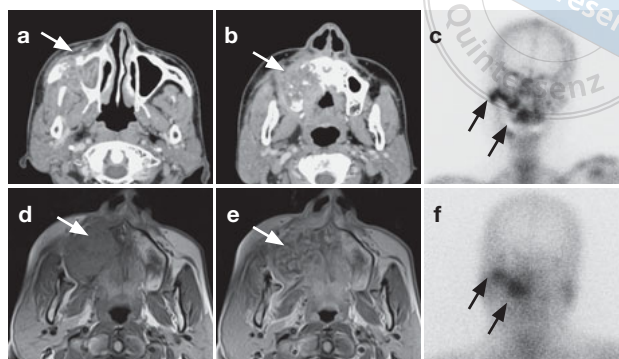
Squamous cell carcinoma of the right side of the maxilla in a 62-year-old male. Post-contrast axial soft tissue algorithm CT (a, b) show a mass lesion with the destruction of the right maxilla (arrow). Bone scintigraphy shows increased uptake (arrows) (c). On MRI, axial T1-weighted image (T1WI) revealed homogeneous, low-signal intensity (arrow) (d). Post-contrast T1WI showed heterogeneous enhancement (arrow) (e). ^{67}Ga scintigraphy shows increased uptake (arrows) (f).
